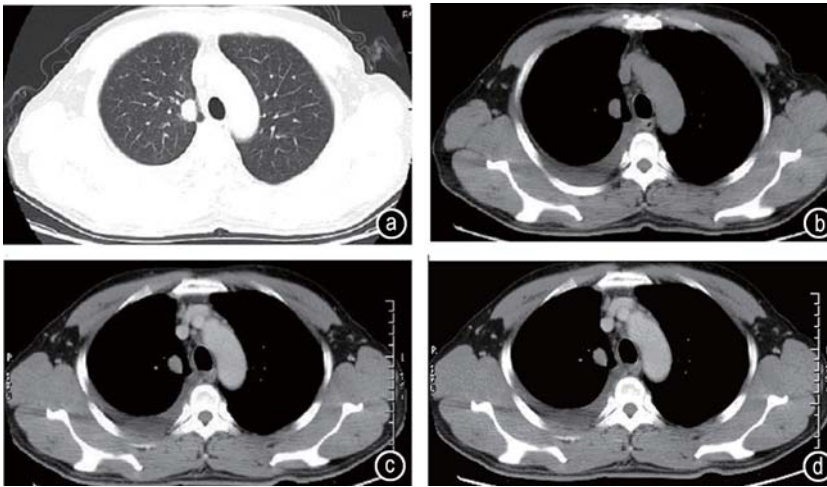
The enhancement pattern of adenocarcinoma of the right upper lobe in a 43-year-old man were detected on CT workstation. (a) The image showed a lobulated tumor in the upper lobe of the right lung; (b) The image revealed a heterogeneous tumor with attenuation value 23.00 HU on the precontrast scan; (c) The lesion appeared heterogeneous enhancement at 25 s after administration of contrast material with attenuation value 32.00 HU; (d) homogeneous enhancement at 90 s after administration of contrast material with attenuation value 48.00 HU
